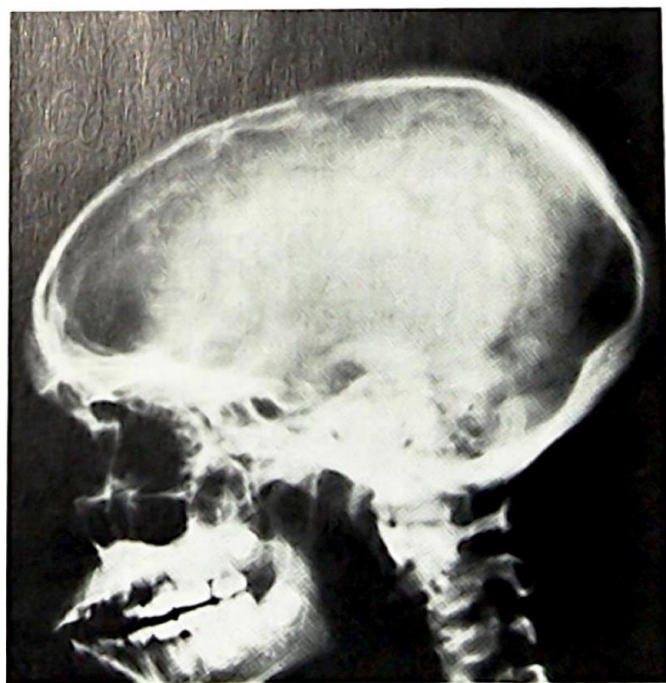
X-ray of patient's daughter's skull — showing sclerosis at the base.
